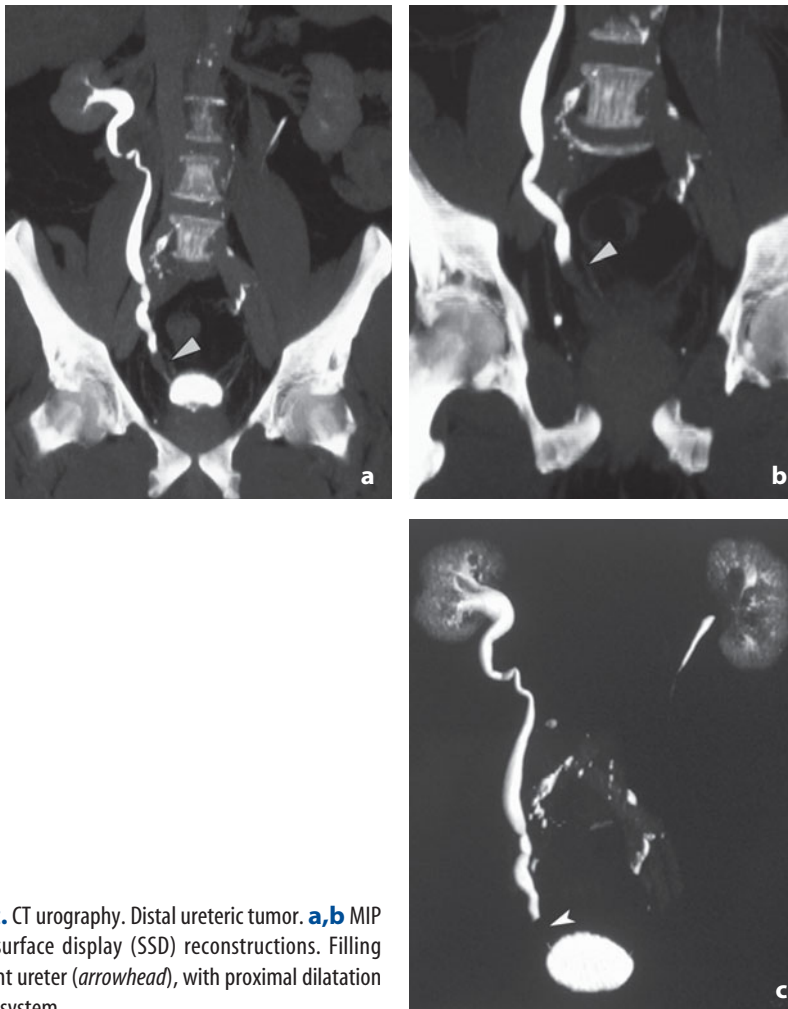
CT urography. Distal ureteric tumor. a,b MIP and c shaded surface display (SSD) reconstructions. Filling defect in the right ureter (*arrowhead*), with proximal dilatation of the collecting system
